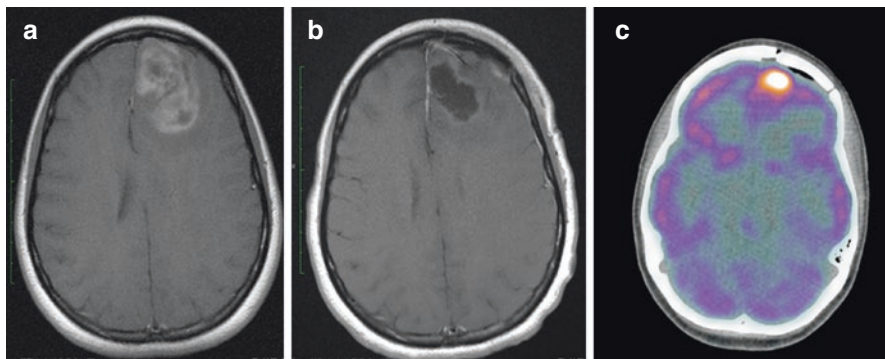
(a–c) Axial post-contrast T1WI (a, b) and axial fused ^{18}F -FDG PET/CT (c) demonstrated an enhancing left frontal lobe mass in a patient diagnosed with GBM (a). Follow-up post-operative MR imaging shows postoperative changes in the left frontal lobe with no convincing enhancement of residual tumour (b). Additional functional imaging with ^{18}F -FDG PET/CT shows an avid focus in the left frontal lobe (c) which is consistent with active residual disease.
